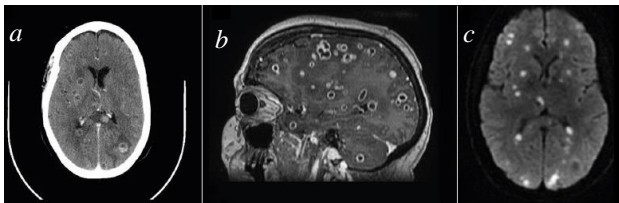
Image example of CTScan (computed tomography) (a) Represents axial section with skull bone, (b) Sagittal section, (c) Axial section without skull bone. Source: Figure extracted from *Multiple brain abscesses due to Streptococcus milleri*. *Revista de Neurología* [VII].
